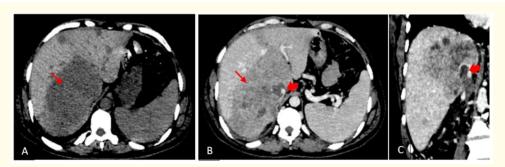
A: Non enhanced computed tomography in axial section showing a large hypodense tumor of the right liver (arrow).
